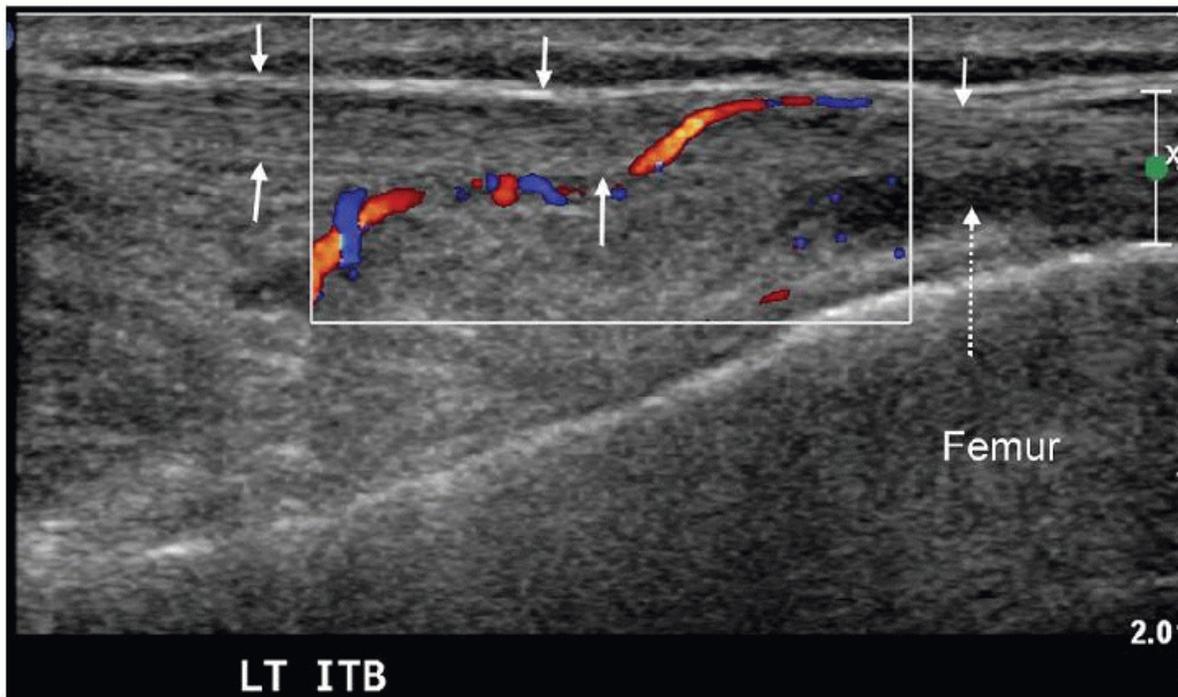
Longitudinal color Doppler image demonstrating ITBFS. ITB (solid arrows). Fluid deep to ITB (dashed arrow). Note hyperemia in and deep to the ITB.
